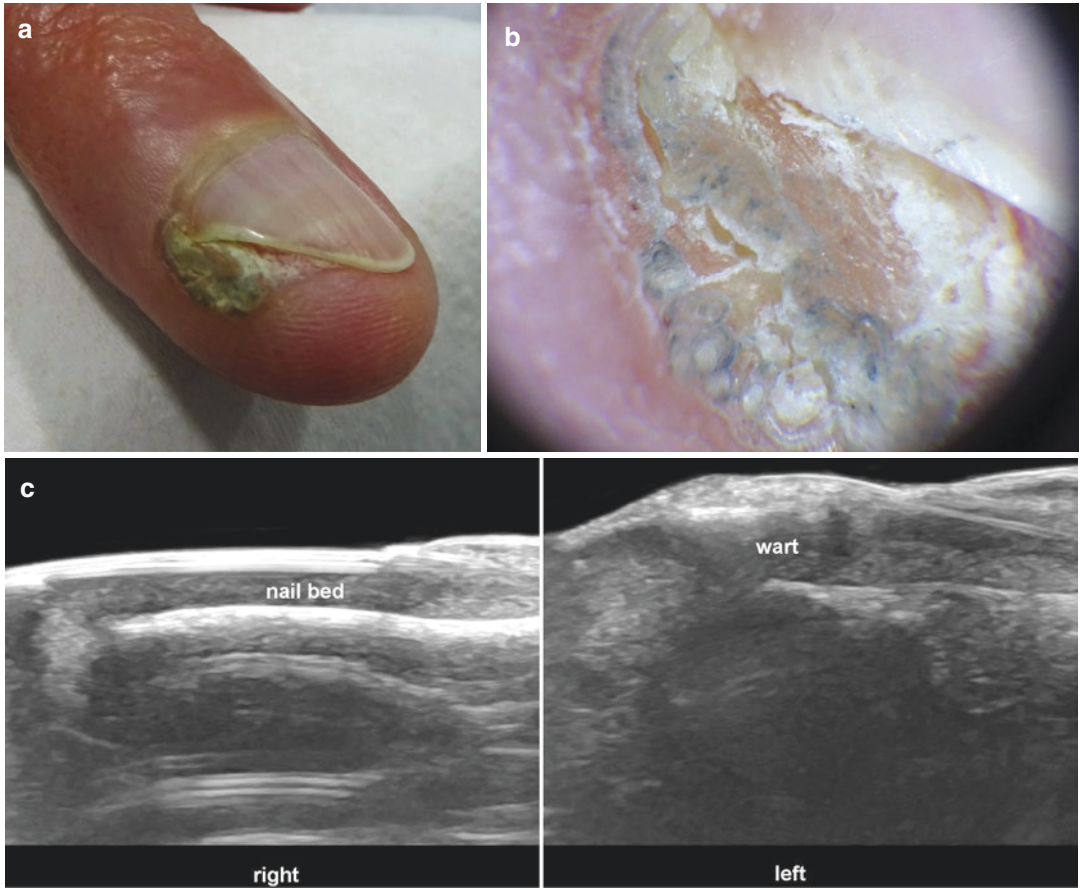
(a–c) Subungual wart. (a) Clinical, (b) dermoscopy, and (c) ultrasound (grayscale, side-by-side comparative images; right versus left ring fingers) present
